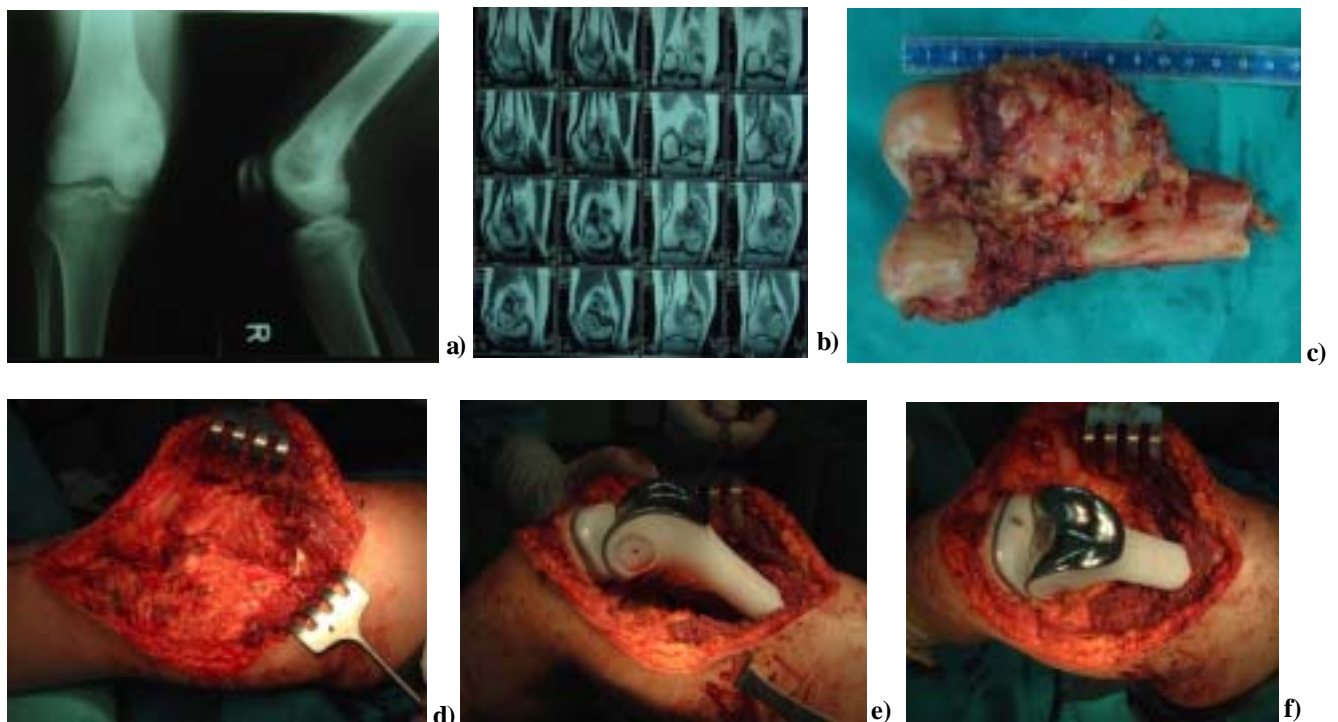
a) x-ray of high-grade chondroblastic osteosarcoma of right distal femur in a girl aged 17; b) anterior and lateral MRI view of the lesion; c) photo of the resected tumor; d) tumor site ready for reconstruction; e, f) reconstructed right femur and knee (Link modular endoprosthesis).
